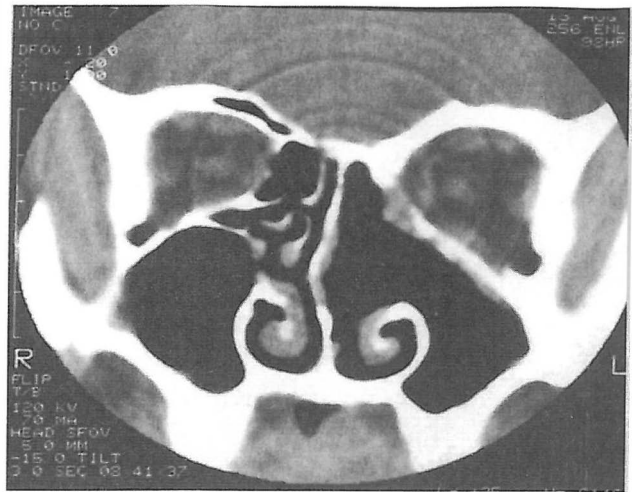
Postoperative coronal CT scan.
